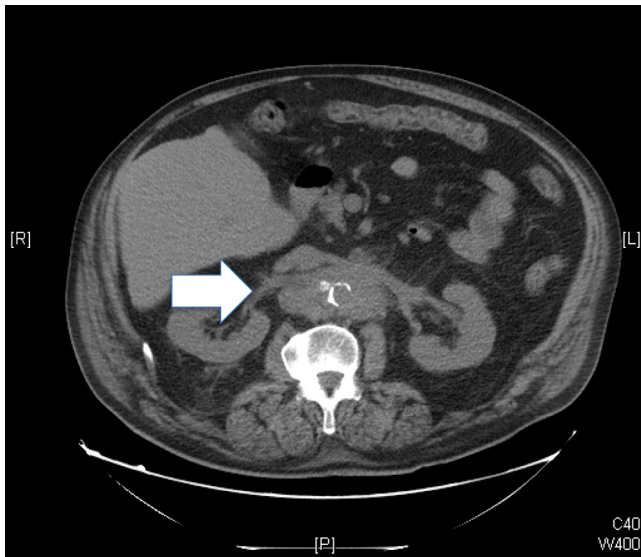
Non-contrast CT of the abdomen and pelvis showing mural aortic calcifications, surrounded by sub-circumferential soft-tissue density (arrow) compatible con retroperitoneal fibrosis.
